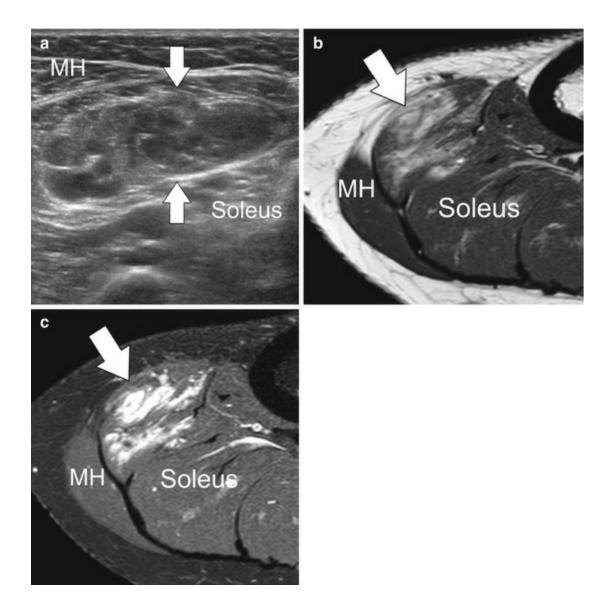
(a) Transverse ultrasound obtained over the medial part of the soleus muscle shows an intramuscular mass (arrows) of mixed echogenicity that was a hemangioma. Corresponding axial T1- (b) and fat-suppressed contrast-enhanced T1-weighted (c) MRI confirm the ultrasound findings. MH medial head of the gastrocnemius muscle
